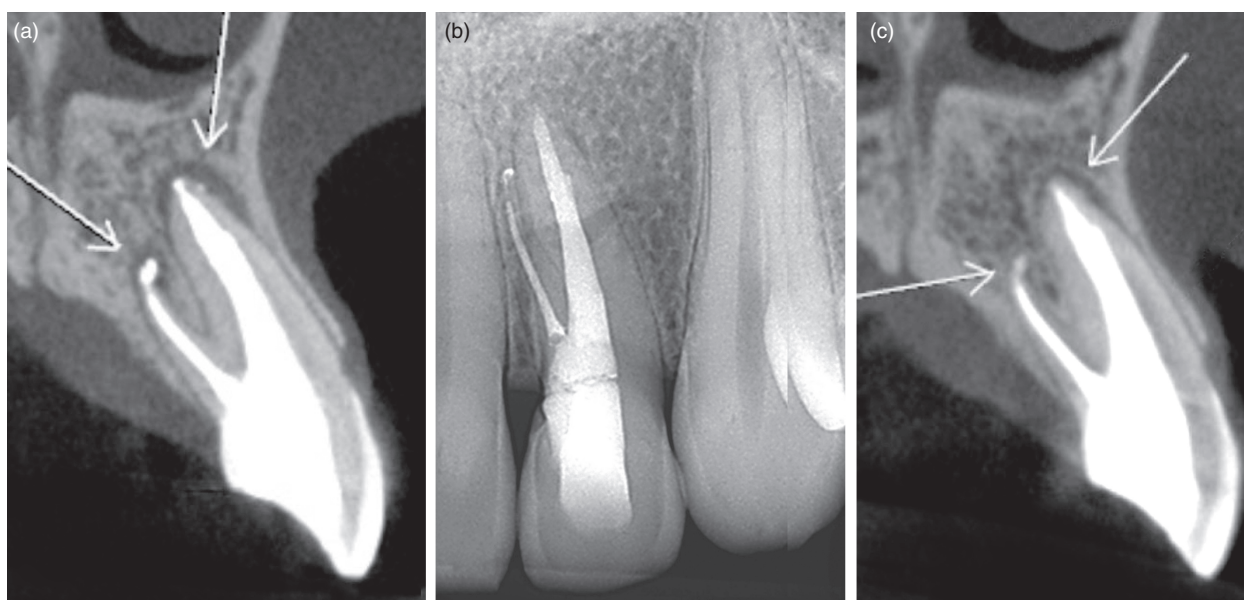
Follow-up examination. (a) After one year, cone-beam computed tomography. (b) After three years, periapical radiograph, and (c) cone-beam computed tomography
